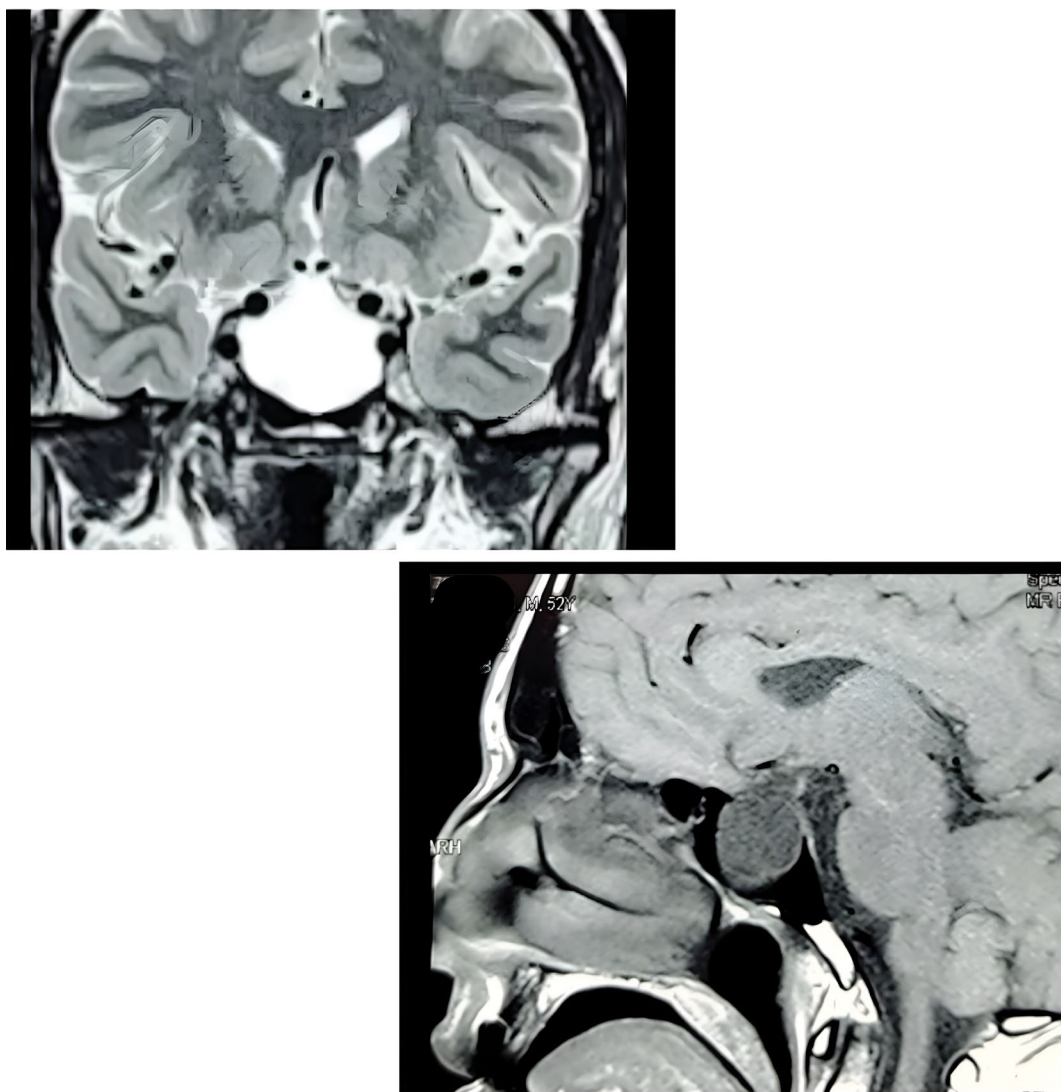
Magnetic resonance imaging (MRI) brain indicated enlarged sella along with a cystic lesion.
